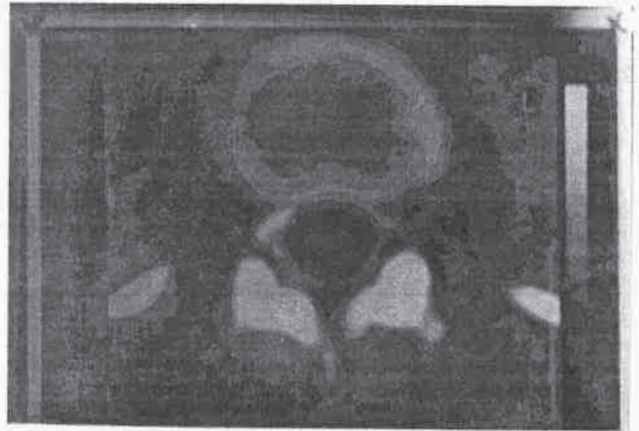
Computed tomographic scan with contrast media demonstrates the tumor with characteristically low attenuation values.
